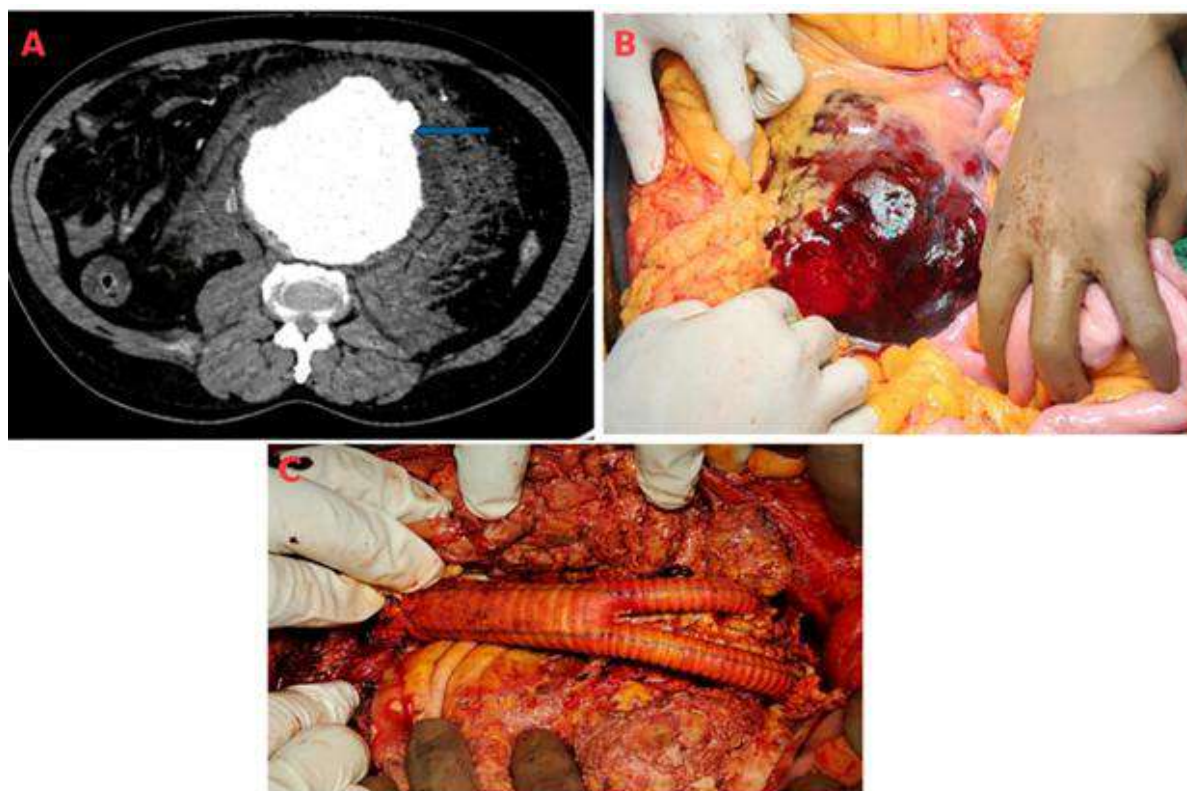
A: CT angiogram showing an infrarenal abdominal aortic aneurysm measuring 10×7 cm (blue arrow), B: intraoperative visualization of posterior wall rupture, and C: surgical repair with placement of a Dacron bifurcated graft (16×8 mm).
